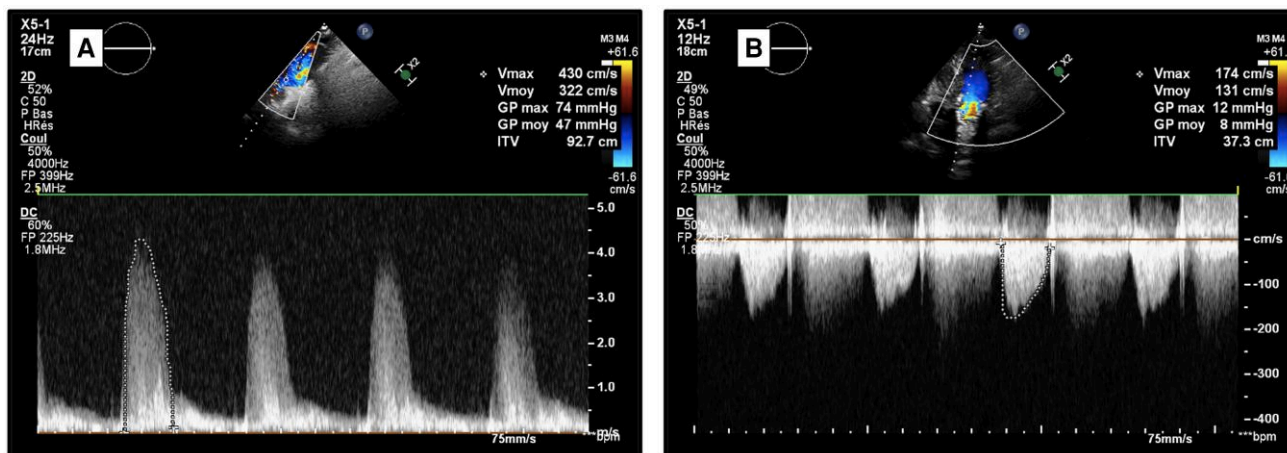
Ultrasound acquisitions before the transcatheter aortic valve replacement showing severe aortic stenosis with a mean gradient at 47 mmHg—suprasternal view (A) dropping to 8 mmHg after the transcatheter aortic valve replacement—apical five-chamber view (B).
